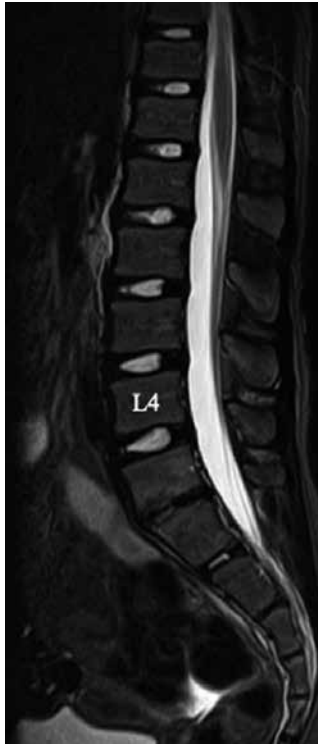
Postoperative MRI scan of the lumbar spine STIR sagittal MRI scan at the 1-month follow-up after surgery showing a decrease in the high signal intensity of the vertebral body, and no increase in the abscess or bone destruction.
